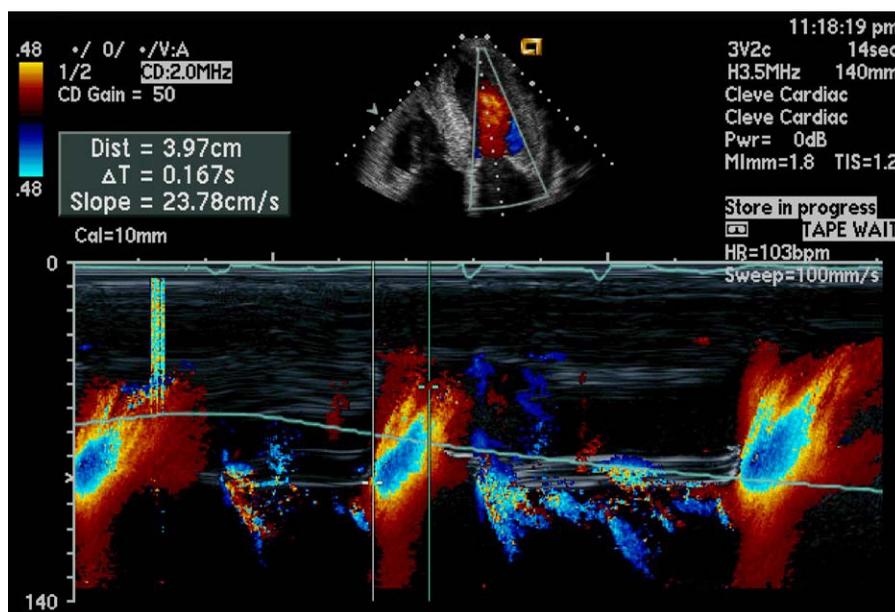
Measurement of color M-mode early diastolic left ventricular filling propagation velocity ( $v_p$ ) in a patient with dilated cardiomyopathy.  $v_p = 24$  cm/s, indicating abnormal LV relaxation. Combining this index with early left ventricular filling pulsed Doppler velocity ( $E = 80$  cm/s) shown in Fig. 8 yields a  $E/v_p$  ratio of 3.3, equivalent to an estimated mean left atrial pressure of 22 mm Hg.
